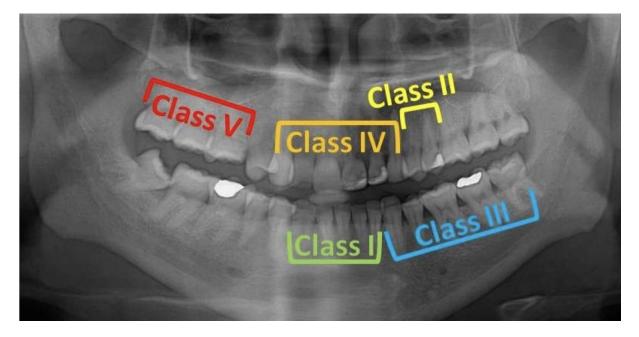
Orthopantomogram with color coded IDSC classification I-V.
